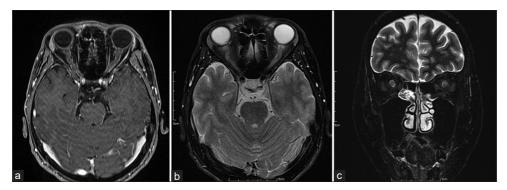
Magnetic resonance imaging (MRI) showed bilateral optic neuritis. (a) Brain MRI (fat-suppressed contrast-enhanced T1 weighted) revealed bilateral tortuous optic nerve with optic nerve and nerve sheath enhancement. (b) Brain MRI (fat-suppressed T2-weighted) showed swollen optic nerves with hyperintense signals. (c) Brain MRI (short-tau inversion recovery) demonstrated enlarged optic nerves with high-intensity signals
